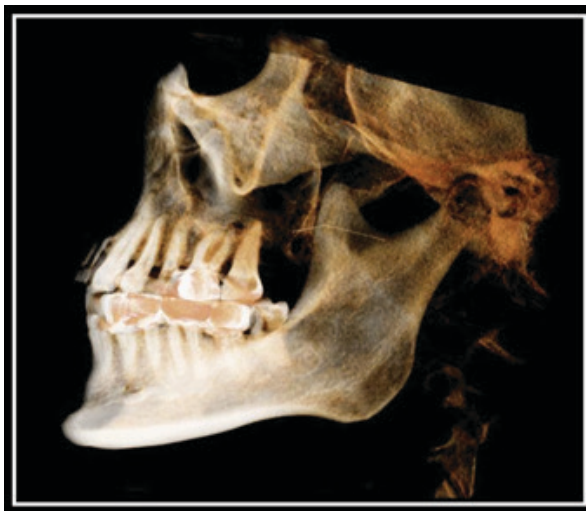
3D reconstruction of the CBCT sections
